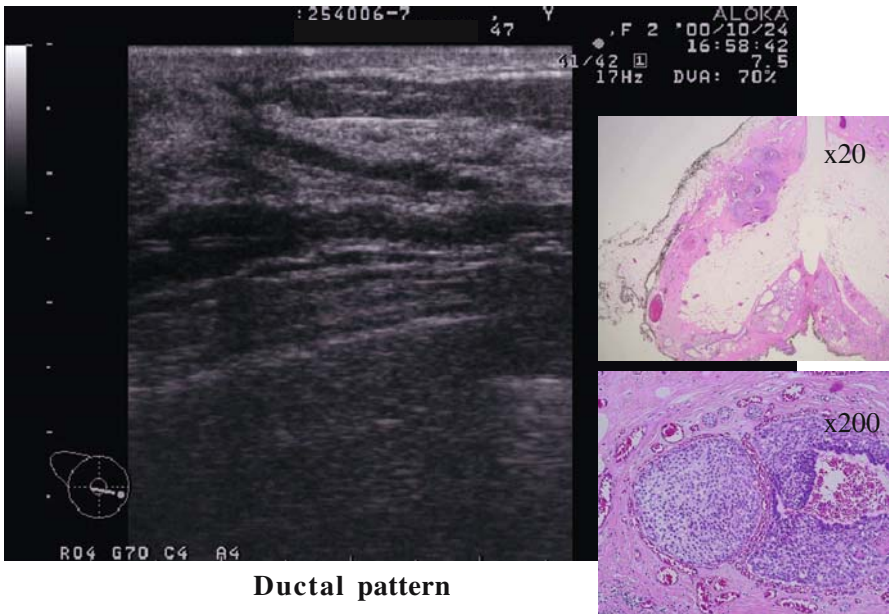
Subtypes of ultrasonic images
